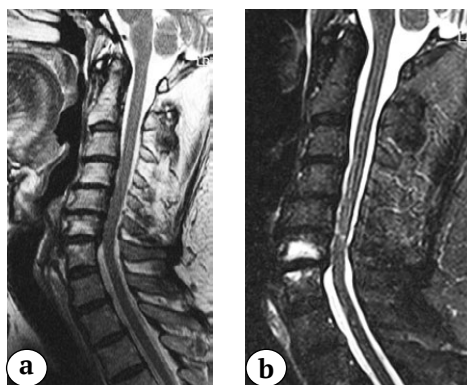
MRI (a — T2 images; b — STIR images): C3–C7 polysegmental degenerative changes, spinal canal stenosis, C6–C7 end plates oedema type I Modic, polysegmental myelopathy C4–C7
